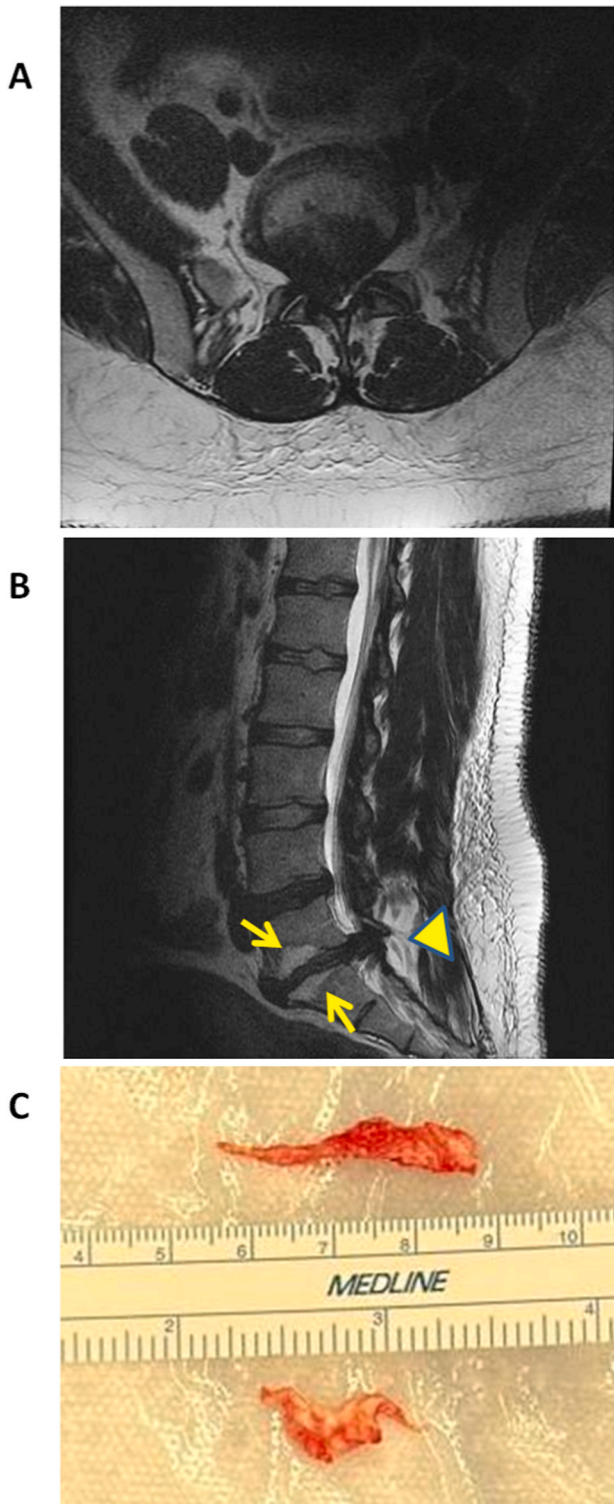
Representation of a severe case of lumbar disc herniation and extrusion at the L5-S1 level during the motor vehicle accident. Axial (A) and right paramid saggital (B) T2 magnet resonance (MRI) images show severe spinal canal and neuroforaminal stenosis (particularly on the right). Also noted are the Modic type I endplate changes (arrows) and paraspinal muscle inflammation (arrow head). (C) Pieces of large herniated lumbar disc were removed during the surgery through minimally-invasive laminotomy and discectomy (MILD).
